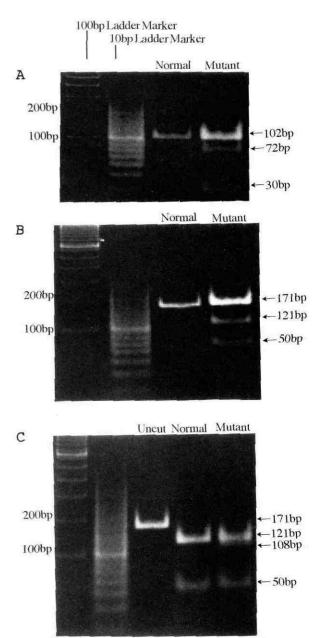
Result of PCR-RFLP analysis using restriction enzymes. A. Detection of GGT-to-GAT mutation in codon 12 by using Hph I enzyme. B. Detection of CAA-to-CTA mutation in codon 61 by using Xba I enzyme. C. Detection of CAA-to-CGA mutation in codon 61 by using Taq I enzyme.
